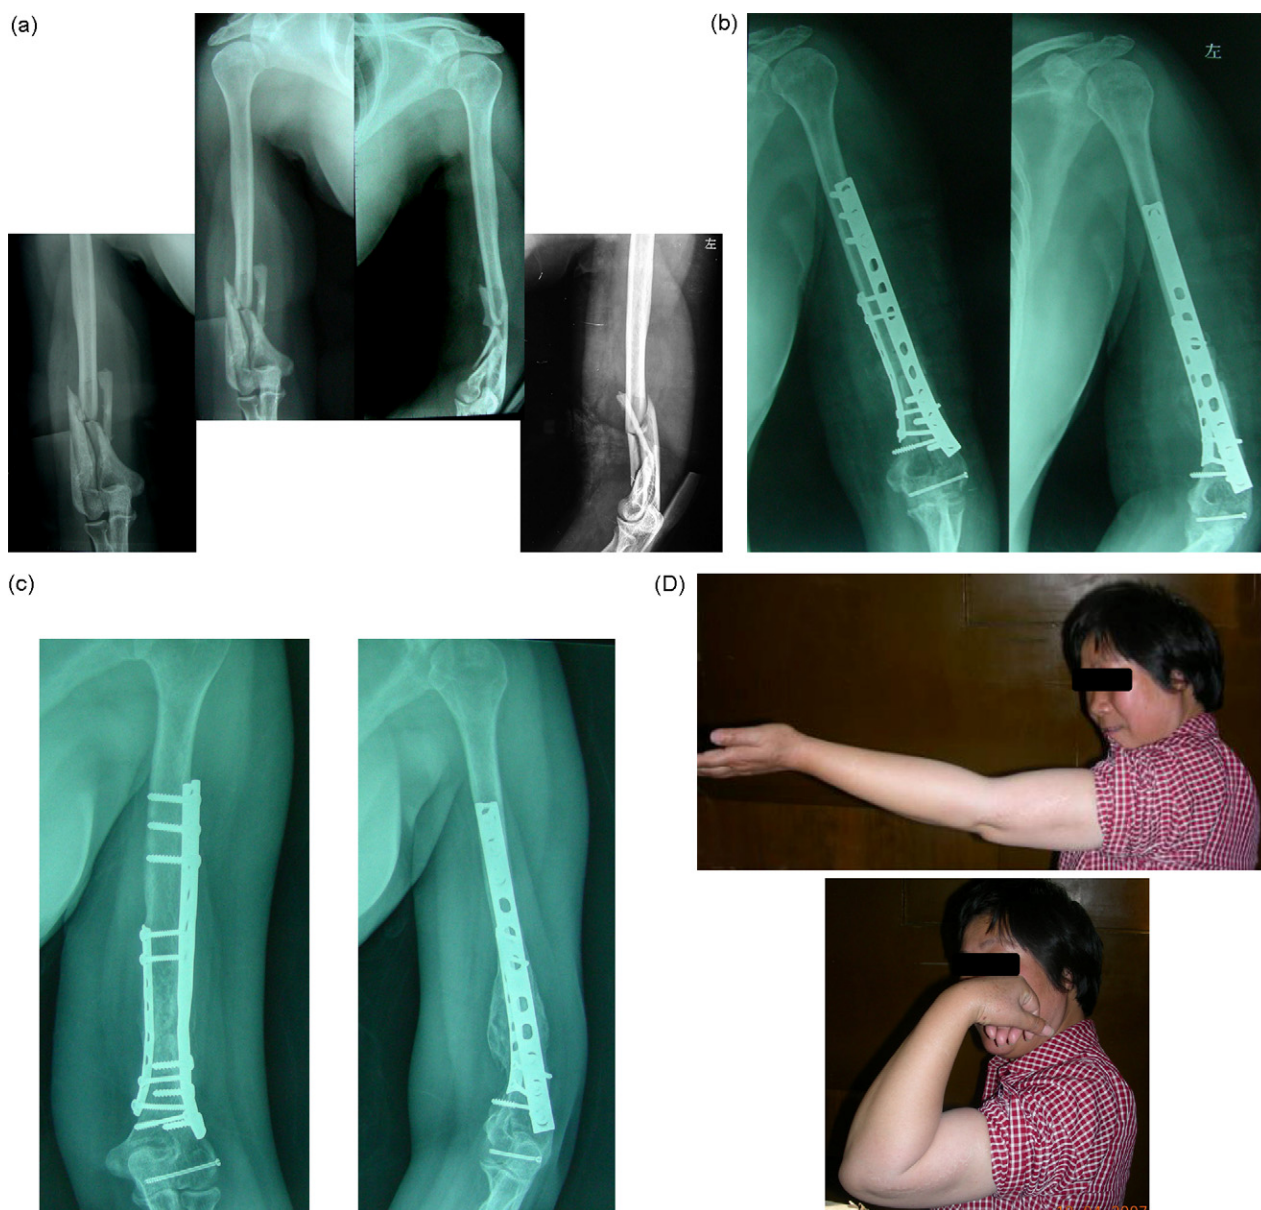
Anteroposterior and lateral radiographs show distal intra-articular humeral fractures extending into the distal third of the humeral shaft (13C2, OTA). (A) Open reduction with internal fixation was applied through a tri-incision approach. (B) Significant callus 6 weeks after the operation at the fracture site of the humeral shaft. (C) Follow-up 40 months after the operation. (D) Excellent function of the injured elbow.
